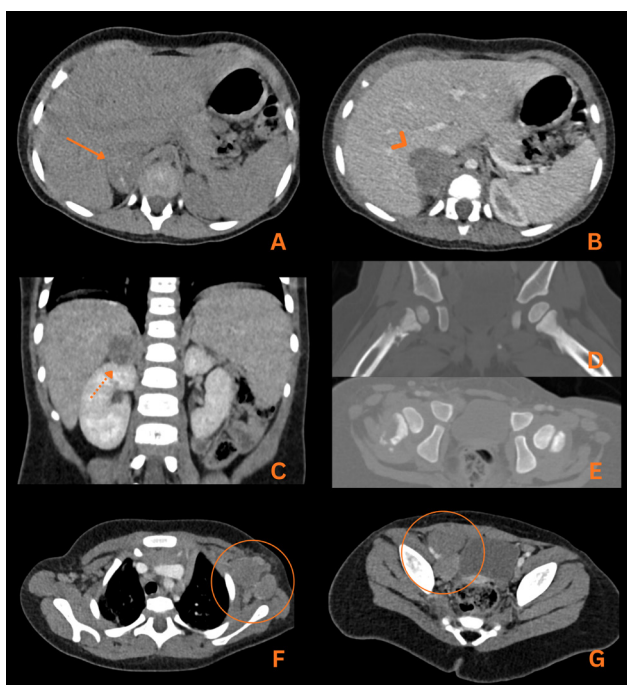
Axial non-contrast CT image (A) shows a heterogeneous right adrenal mass (arrow) with coarse calcifications. Post-contrast images (B, C) show mild enhancement, with extension into the liver (arrowhead), contact with the inferior vena cava with no evidence of encasement and contact with the superior pole of the right kidney (dashed arrow). Coronal reconstruction (D) and axial image (E) show the previously identified lytic femoral lesion with cortical disruption consistent with a pathologic fracture. Axial images (F, G) confirm the previously noted lymphadenopathy (circles). These findings support metastatic adrenal neuroblastoma.
